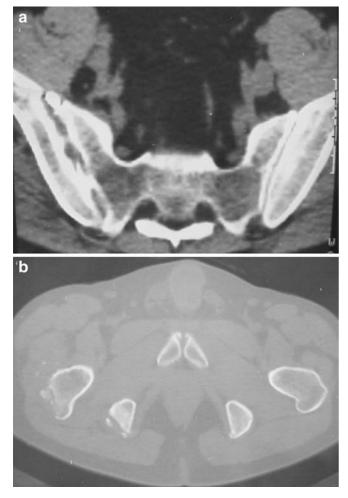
a Axial computer tomography image showing erosions of the articular surface of the right sacroiliac joint. b Axial CT-image depicting destruction at the right trochanter and ischial tuberocity. Soft tissue calcifications are delineated in both sites
